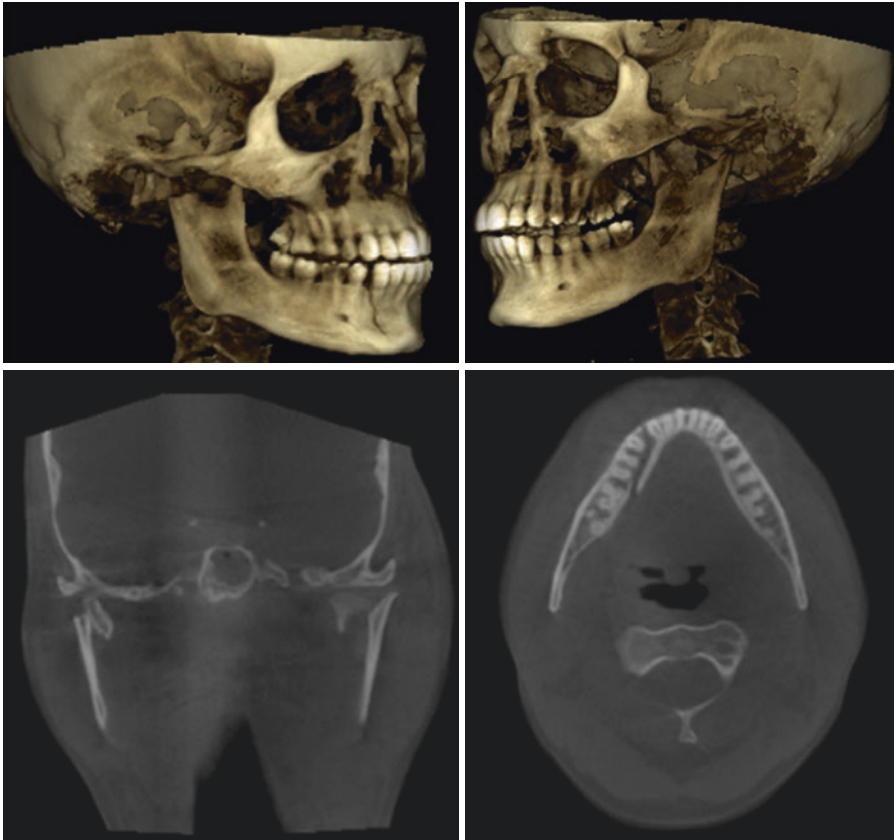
This large field of cone beam computed tomography was taken on an 18-year-old man, who celebrated his day after his 18th birthday in hospital after being kicked in the face at a party. He suffered multiple jaw fractures: bilateral condylar neck fractures (especially well visible on the coronal view), right body of mandible fracture (especially well visible on the axial view), and a left-hand-side coronoid process fracture (upper right-hand-side image)
